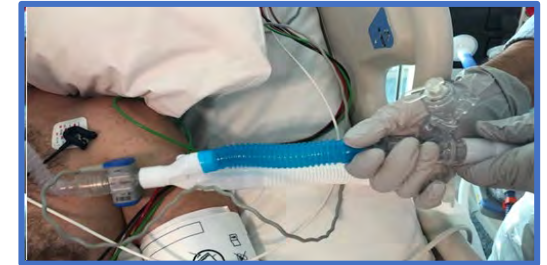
depicts an ultrasonic nebuliser attached to the inspiratory limb of ventilator tubing in the RBWH Intensive care unit
